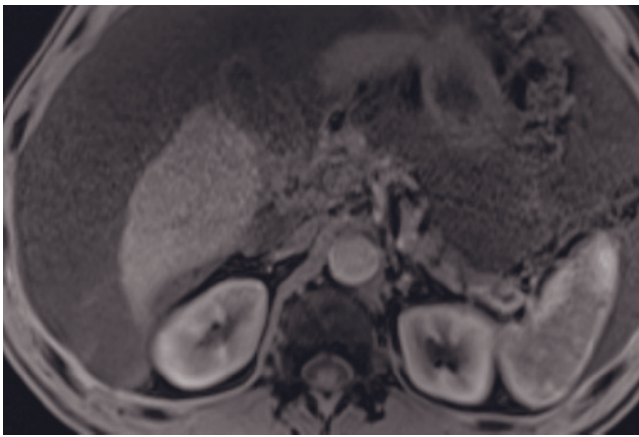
(Continued) T2-weighted fat-suppressed SS-ETSE (g), SGE (h), and immediate (i, k) and 90-s (j, l) postgadolinium fat-suppressed 3D-gradient echo images obtained at 3T show similar findings with multiple hypovascular HCCs.
